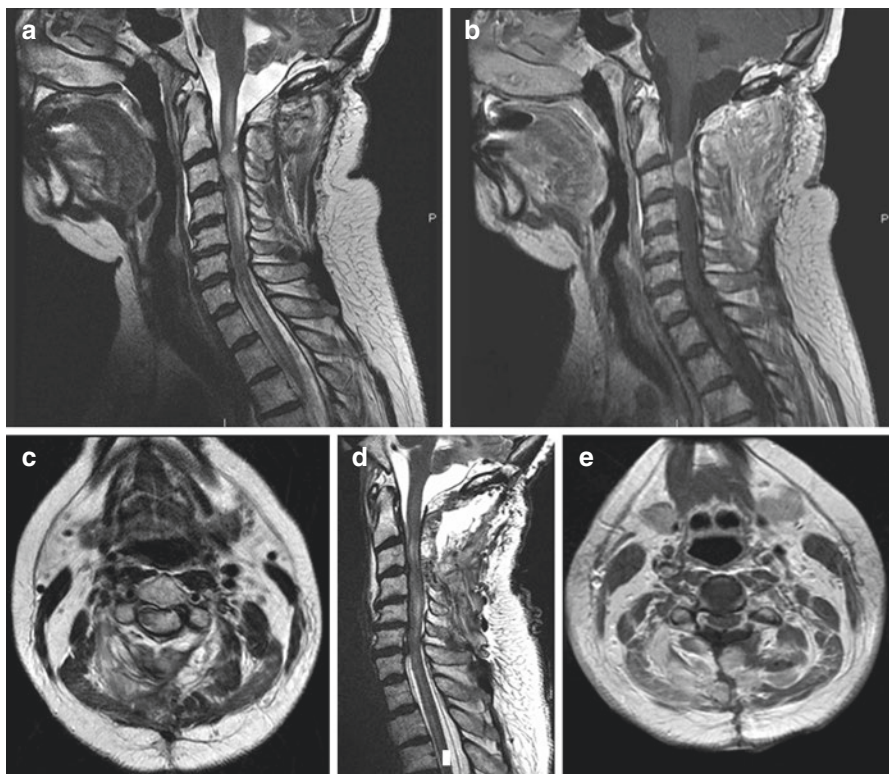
An MRI of cervical spine 2.5 month after initial cerebellar metastasis resection. (a) Sagittal T2-weighted MRI. (b) Sagittal T1-weighted postcontrast MRI. (c) Axial postcontrast T2-weighted MRI showing intradural extramedullary tumor at C3. (d) Sagittal T2-weighted MRI. (e) T2-weighted MRI showing tumor resection
